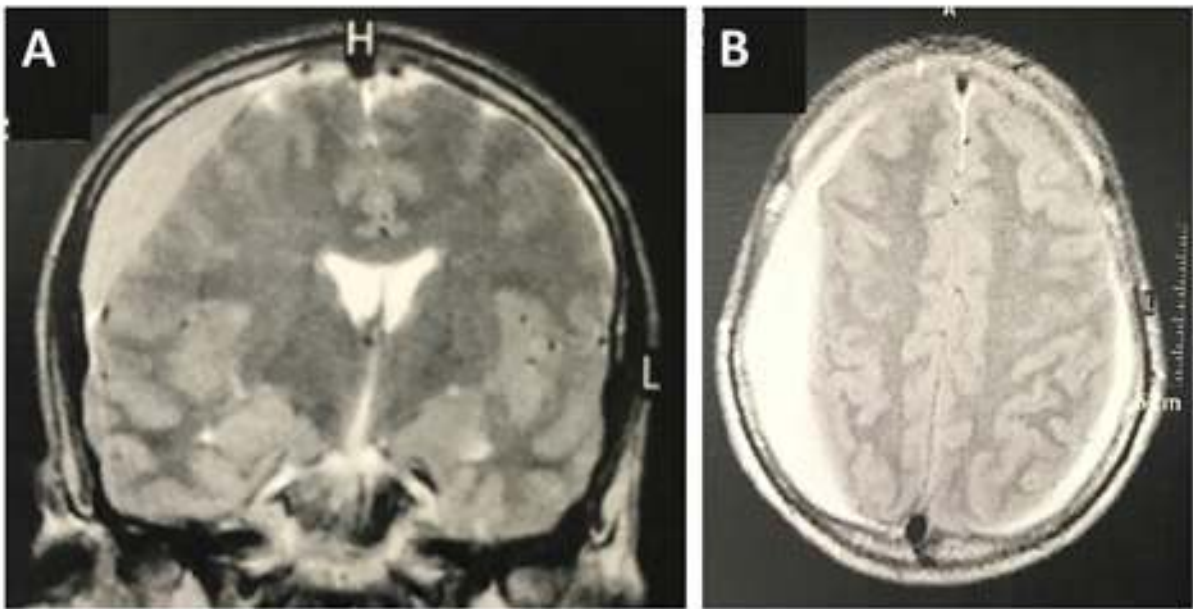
A, coronal view on MRI of the skull showing a supratentorial subdural hematoma with features of chronicity and deviation of midline structures. B, MRI transverse view showing the typical image of a right supratentorial chronic subdural hematoma.
